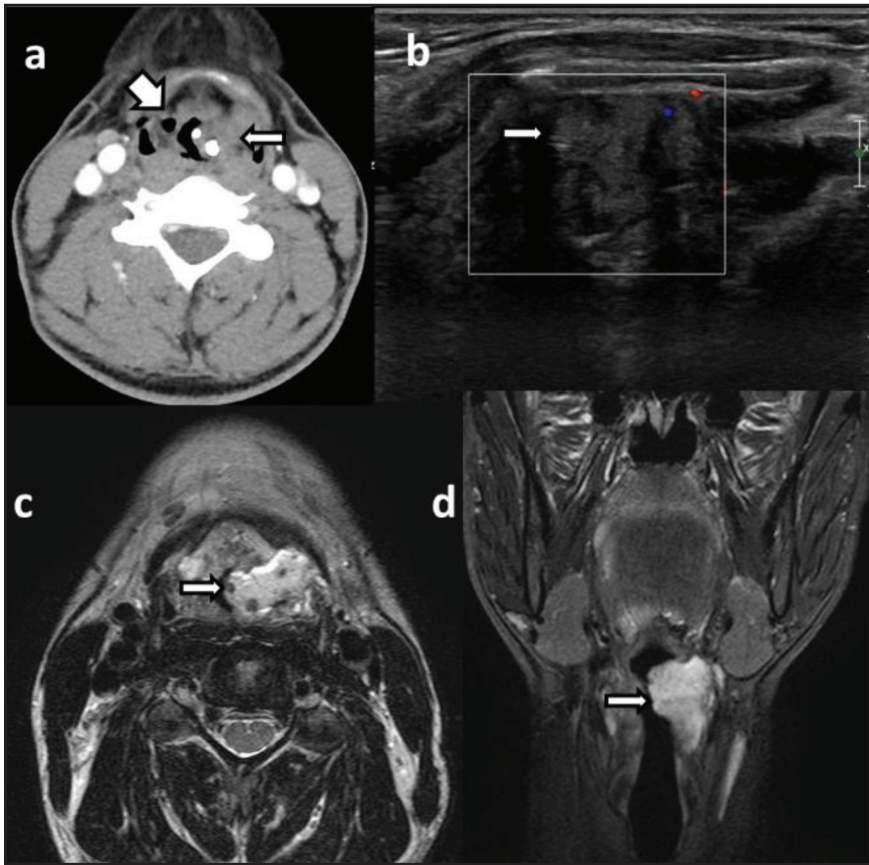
42-year-old female with slow-flow vascular malformation. (a) CECT of the neck demonstrating a lobulated soft tissue lesion containing multiple phleboliths involving the left AE fold (long arrow) and an incidental right external laryngocele (short arrow). (b) The lesion is hypoechoic on USG with low-level echoes and no internal vascularity. (c) On MRI, the lesion is hyperintense on T2WI and T2-STIR.
